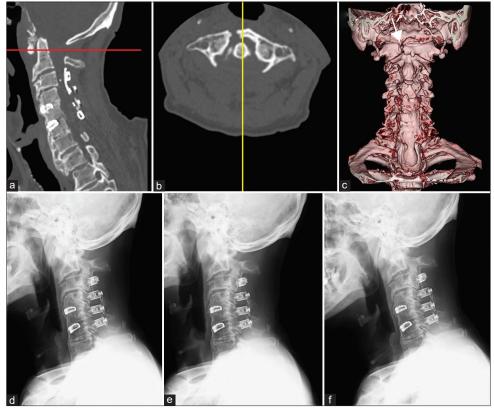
Sagittal-view (a) and axial-view (b) after onset of neck pain showed right C1 anterior arch fracture. (b) was at the level of the red line in the sagittal-view image (a). (a) was at the level of the yellow line in (b). Anterior view (c) three-dimensional computed tomography scan. White arrow indicates right C1 anterior arch fracture. Cervical radiographs indicated instability between C1 and C2 (d: lateral neutral view, (e: extension view, (f: flexion view).
